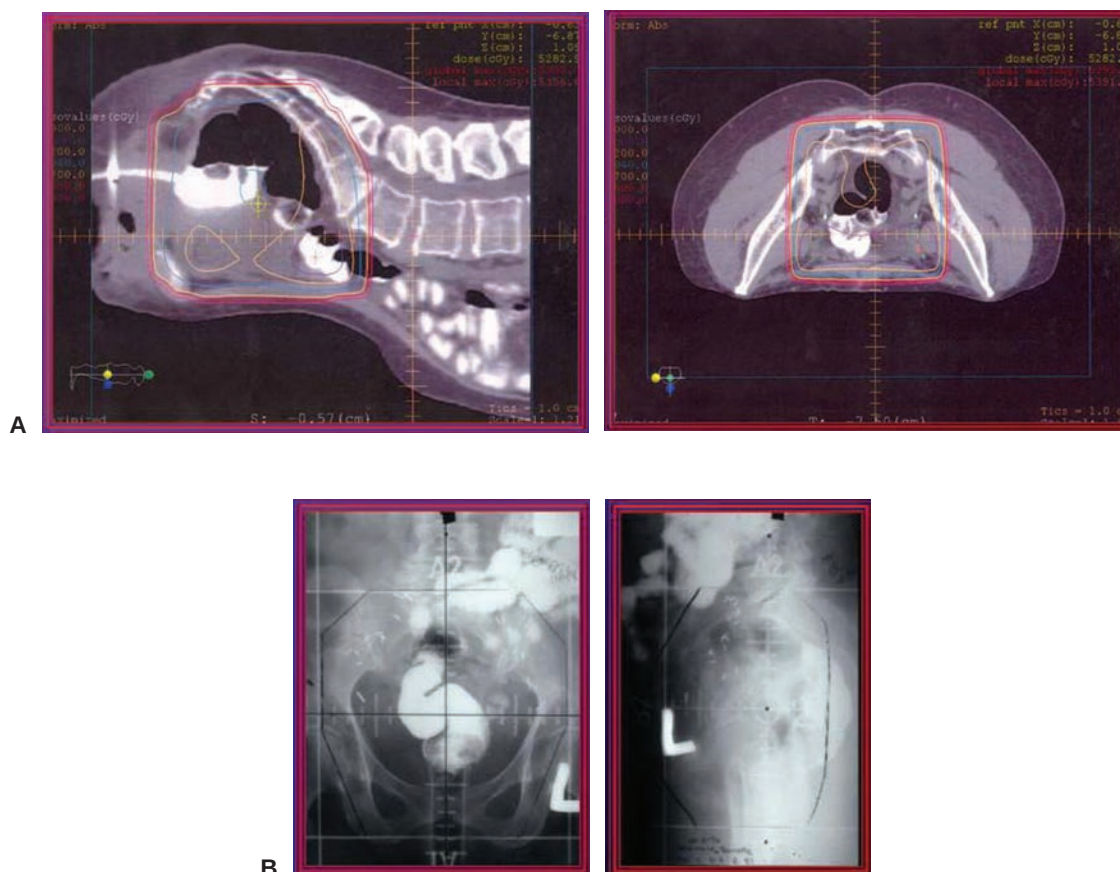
A: Utility of the prone technique for small bowel displacement as shown on a sagittal and axial CT scan of a patient with endometrial cancer planned in the prone position. B: Radiographs of the pelvis showing significant amount of small bowel in the radiation fields.
